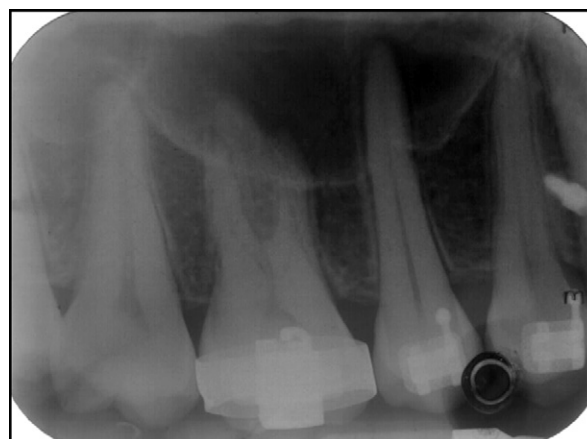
A, Clinical photograph and B, periapical radiograph with wire guide placed in the first premolar area.
